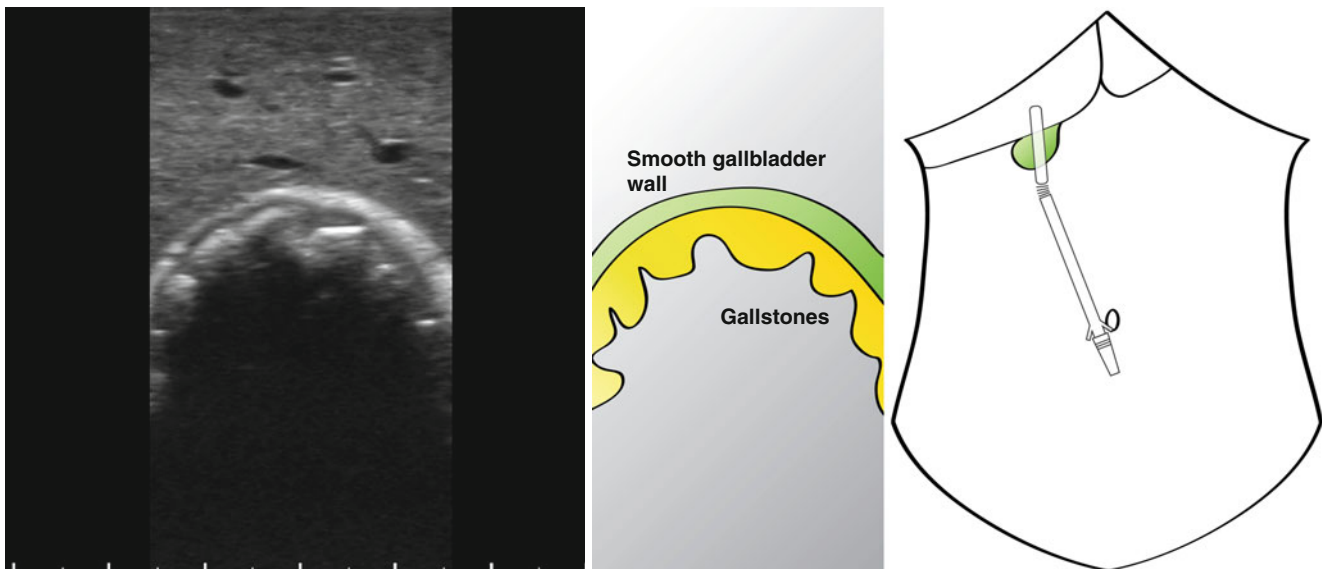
Laparoscopic ultrasound examination of gallbladder described as suspicious on preoperative imaging. The gallbladder is seen to be smooth and relatively thin walled, with multiple gallstones present within the lumen. No infiltrating lesion was seen (Also see Video 14.7)
